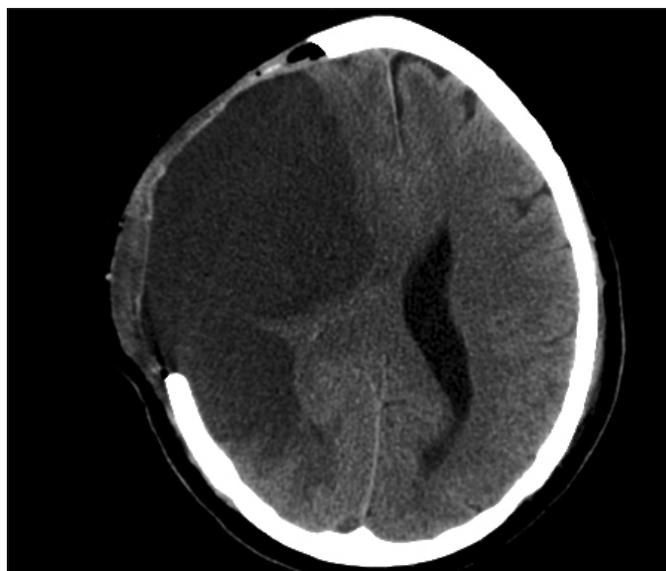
A CT brain scan following decompressive hemicraniectomy. Note the area of infarction extending beyond the limits of the bone flap posteriorly.
